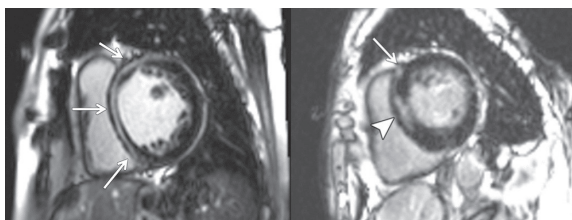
Late contrast enhancement in the mid-myocardium in patients with dilated cardiomyopathy and late contrast in the interventricular septum and biventricular junction in patients with hypertrophic cardiomyopathy. (Source: Ohta, Y. et al. (2018) *Myocardial delayed enhancement CT for the evaluation of heart failure: comparison to MRI Radiology*, 288(3), 682-691.) (12)
